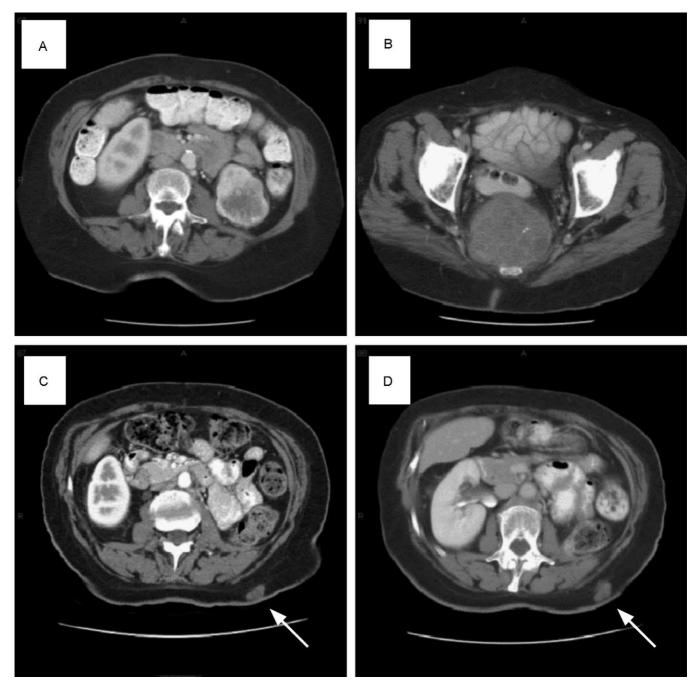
Abdominal and pelvic computed tomography showing (A) primary left renal tumor, (B) primary sacral chordoma, and (C) and (D) metastatic chordoma in subcutaneous flank tissue in area of prior posterior port site used for initial laparoscopic retroperitoneal radical nephrectomy.
